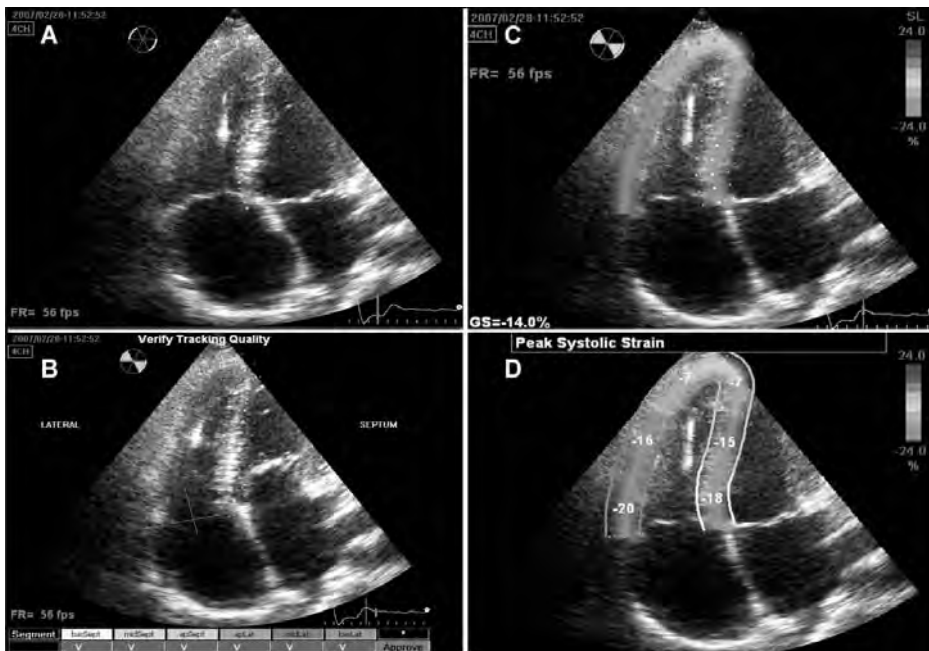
2D Speckle-tracking Strain Analysis of the Right Ventricle. Right ventricular longitudinal strain analysis in the designated user interface. Panel A demonstrates how first the endocardial border is delineated in the apical 4-chamber view. Based on this contour, the interventricular septum and the right ventricular free wall are tracked automatically. The user optimizes the tracking quality, by adjusting the aforementioned contour and by altering the region of interest (ROI), which corresponds to the width of the tracking (Panel B). Thereafter, the program calculates global strain (GS) based on a weighted average of three septal and three right ventricular free wall segments (Panel C and D). FOR COLOR EXAMPLE, SEE CHAPTER 1, FIGURE 3.
